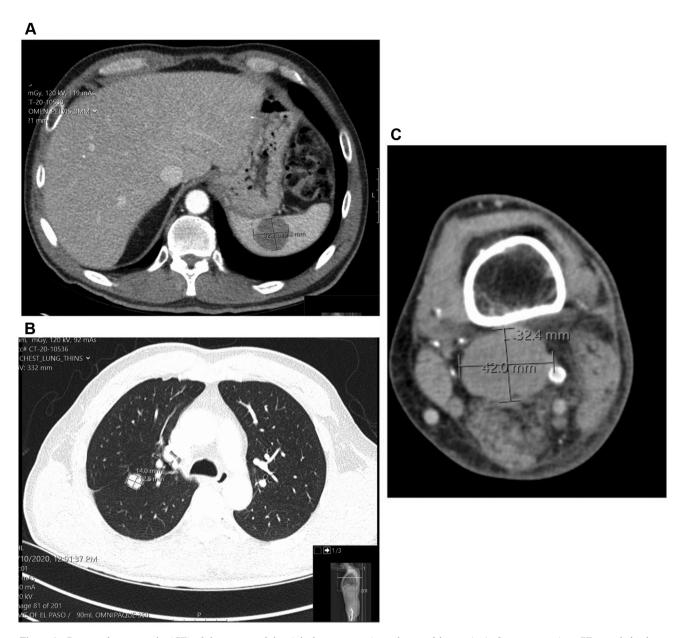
Computed tomography (CT) of the tumors of the right lower extremity, spleen and lungs. A: At first presentation, CT revealed a large primary mass involving the proximal leg and the popliteal fossa, measuring up to  $14 \times 10 \times 16$  cm, with encasement of the popliteal vessels and proximal anterior tibial, peroneal and posterior arteries and veins (November, 2019). B: Two irregular/lobulated solid nodules were also found in the right upper and middle pulmonary lobes (November, 2019). The patient refused treatment. C: The patient returned and positron-emission tomography/CT showed apparent asymmetric thickening of the distal rectal wall up to 1.6 cm, an enlarged 8.5 mm right lower lobe pulmonary nodule, and an enlarged  $3.2 \times 2.9$  cm hypodense splenic mass more pronounced in the lower pole of the spleen (March, 2020).
